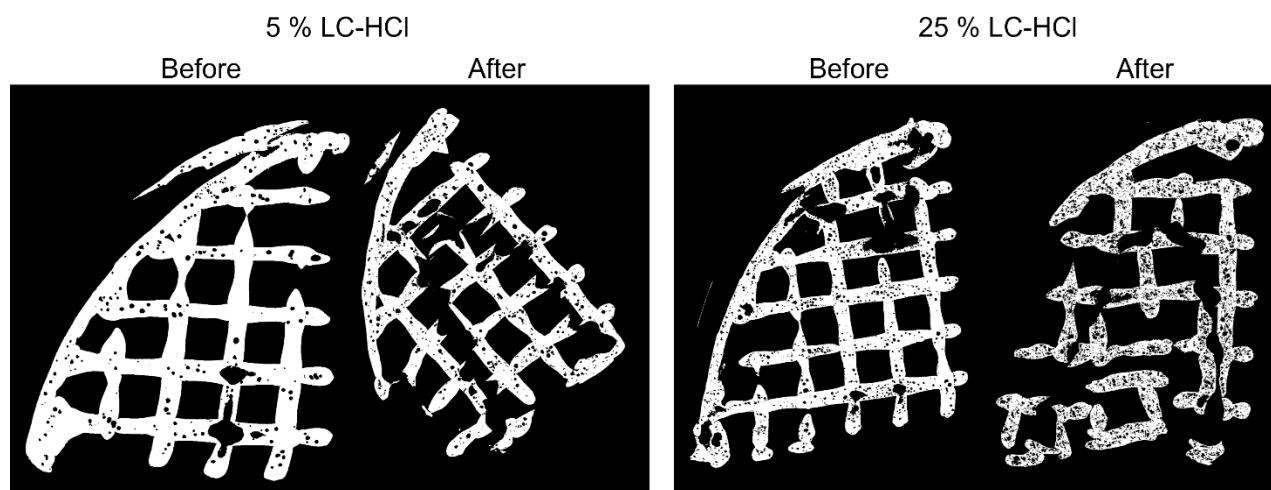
$\mu$ CT images of 5 % (left) and 25 % (right) LC-HCl-loaded PCL inserts before and after dissolution studies.
